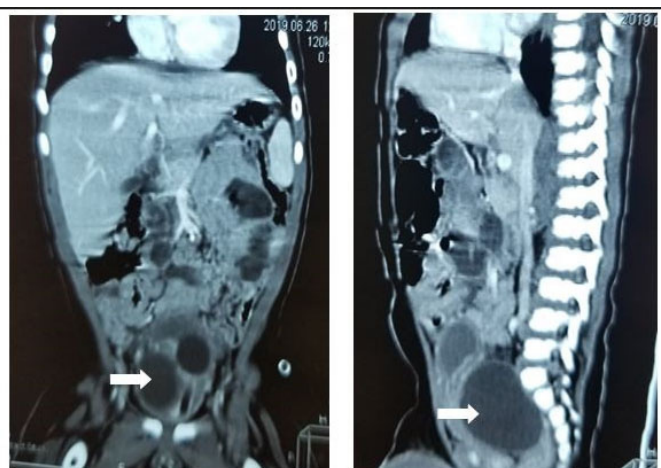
Coronal and sagittal sections of CT-scan abdomen showing cystic mass in the pelvis in pre-sacral region abducting bladder anteriosuperiorly and sacrum posteriorly (arrow).
